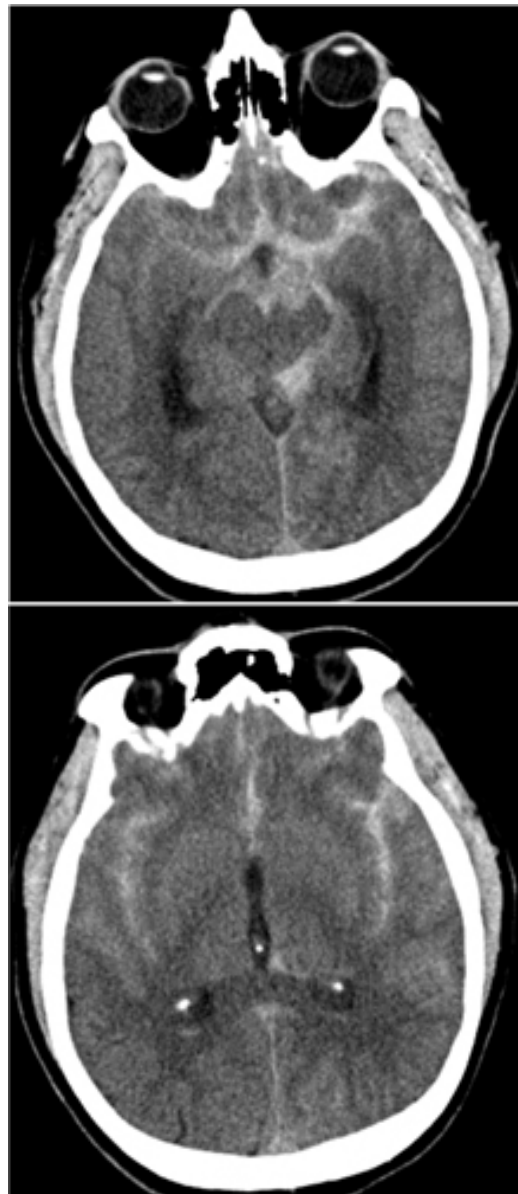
brain CT showing subarachnoid hemorrhage from a ruptured posterior cerebral artery aneurysm
